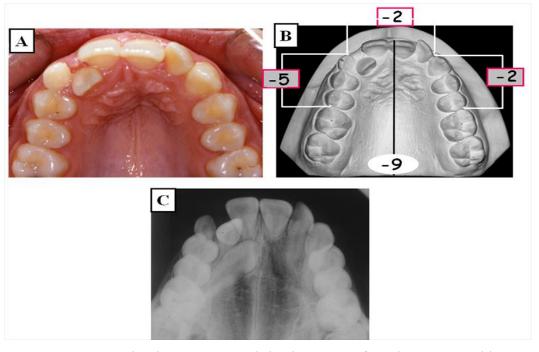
A-C: Palatal impaction and displacement of tooth 13 are visible in A. The space deficiency of approximately 9 mm (B) is a contributing factor to the ectopic position. The radiograph (C) confirms the displacement of tooth 13.
